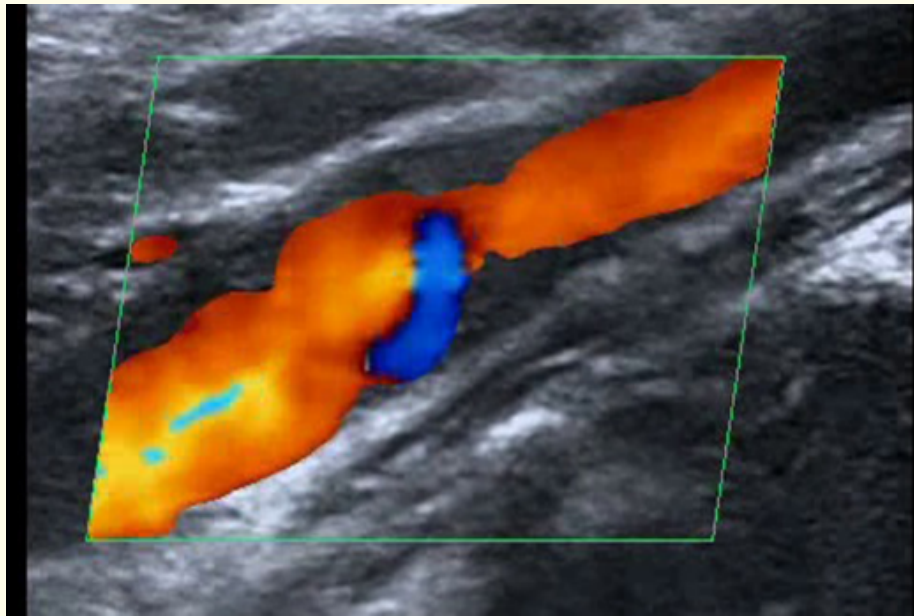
Color Doppler flow image showing whirlpool at the level of the carotid web on the longitudinal section.
